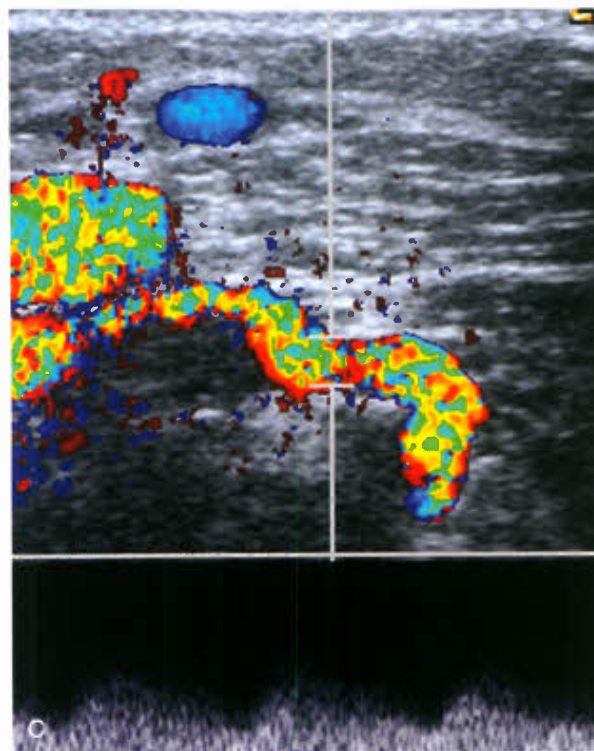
Ultrasonography of arteriovenous malformation of the left upper extremity. Images (A and B) showing increased blood vessels around the eroded bony cortex with turbulent flow and intraosseous dilated draining sac. C: Doppler spectral wave with low-resistance pattern (increased diastolic flow).
